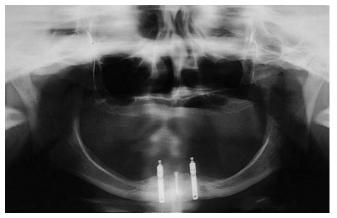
F, Postoperative panoramic radiograph.
